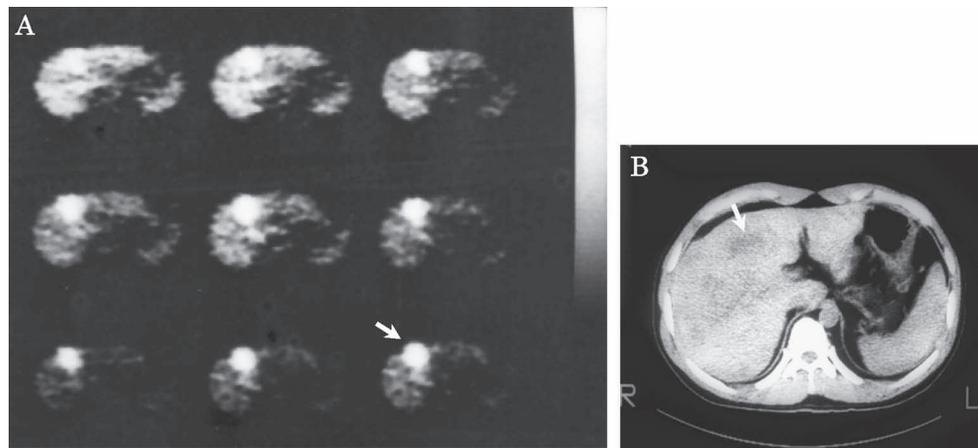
PET imaging of liver metastases with  $^{18}\text{F}$ -FDG.
